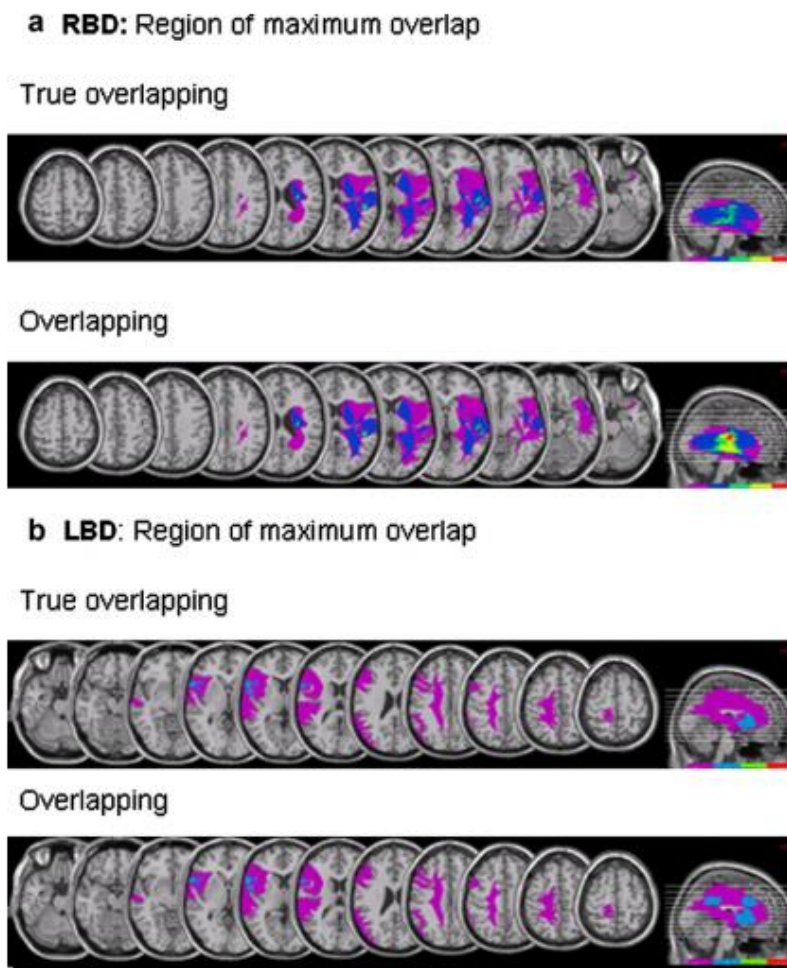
CT/MRI digitalized images of five RBD (a) and of four LBD (b) patients mapped using MRicro software. One color refers to one patient. Dark violet: one ROI (region of interest); red: all ROIs. See text for details.
